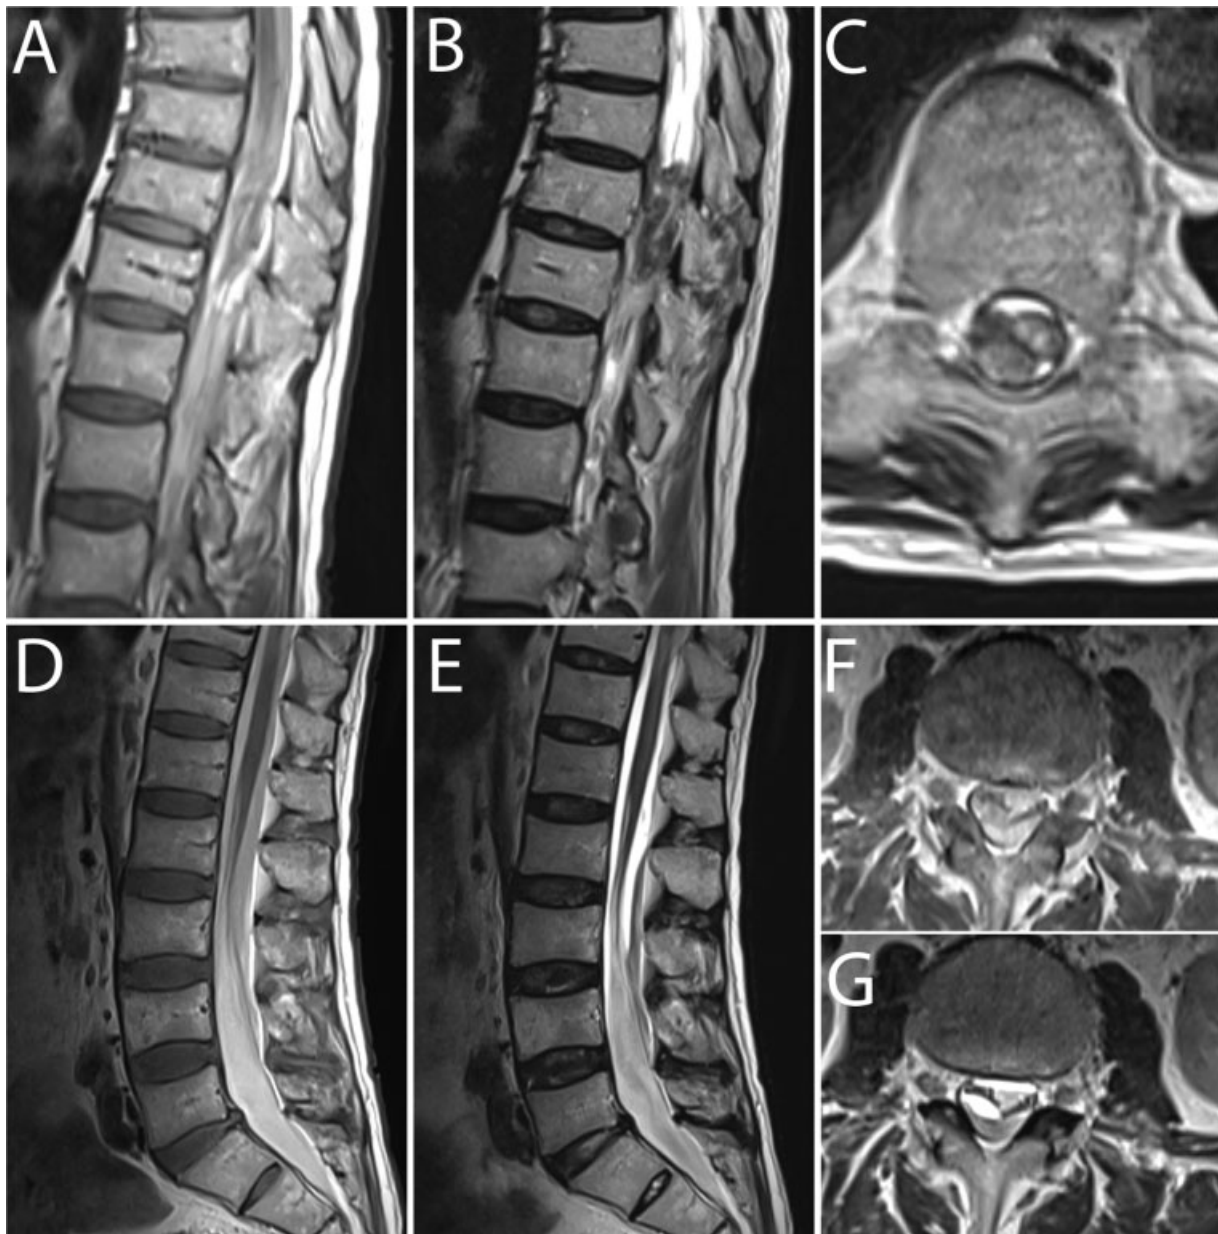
(A) Preoperative sagittal T1-weighted image of the thoracic spine, demonstrating extensive isointense and hyperintense signal reflecting intrathecal blood products. (B) Preoperative sagittal and (C) axial T2-weighted image of the thorax, demonstrating dorsolateral acute subdural hematoma with greatest degree of spinal cord compression at the level of T10. (D, E) Preoperative sagittal T1-weighted and T2-weighted images showing extensive, relatively homogeneously hyperintense acute blood through the distal lumbar intradural space. (F, G) Preoperative axial T1-weighted and T2-weighted sequences of the level of L5, demonstrating casting of the thecal sac by blood products with clumping of spinal nerve roots encased in hematoma.
